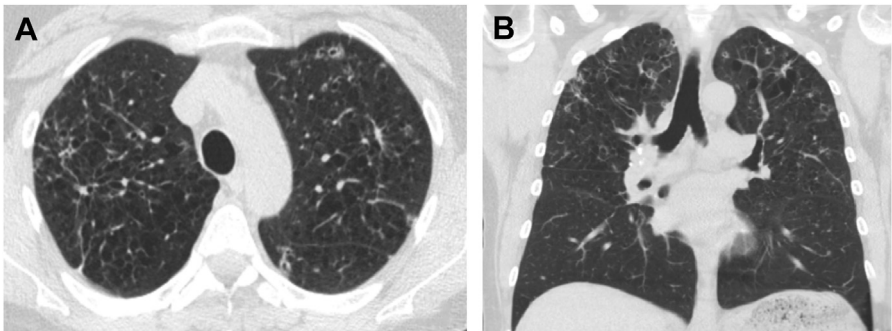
PLCH. (A) Axial CT image showing nodules, cavitating nodules, and cysts in both upper lungs. (B) Coronal CT image showing predominantly upper lung distribution of abnormalities with relative sparing of the lower lungs.
